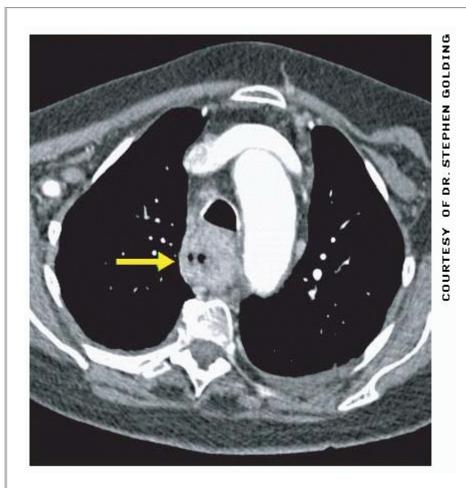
Axial CT of the chest after IV contrast medium showing concentric thickening of the oesophageus (arrow); the diagnosis here is oesophageal carcinoma. Loss of the fatty plane around the oesophagus suggests local invasion. Anterior to the oesophagus is the trachea and next to it is the arch of the aorta.
